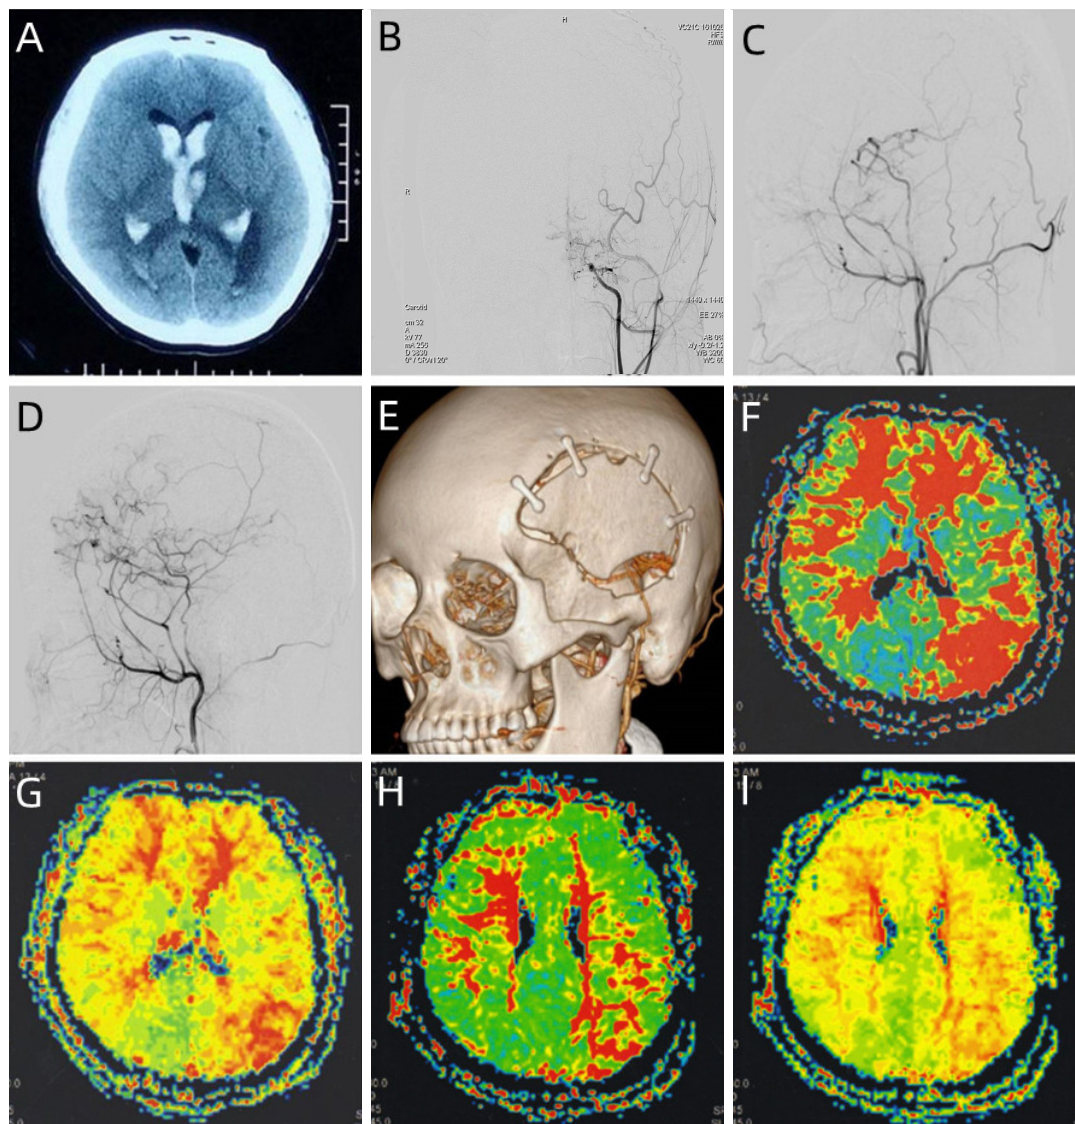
Preoperative and postoperative radiological findings of a 28-year-old woman. (A) Head computed tomography shows left thalamic hemorrhage broken into ventricles. (B) MMD Suzuki stage IV. (C,D) postoperative angiography shows a left STA frontal branch bypass. Long-term angiography shows extensive collateral anastomosis between STA and cerebral cortex, regarded as Matsushima grade A. (E) Postoperative 3D computed tomography scans of the skull. Note the cranial windows to prevent compression at the pedicle of TPF for surgical revascularization. (F-H) MTT changes of MRP before and after surgery, and MTT of the left cerebral hemisphere is significantly shortened. (G-I) TTP changes of MRP before and after surgery, and TTP of the left cerebral hemisphere is significantly shortened too. MMD, moyamoya disease; STA, superficial temporal artery; TPF, temporoparietal fascial flap; MRP, magnetic resonance perfusion; MTT, mean transit time; TTP, time to peak.
